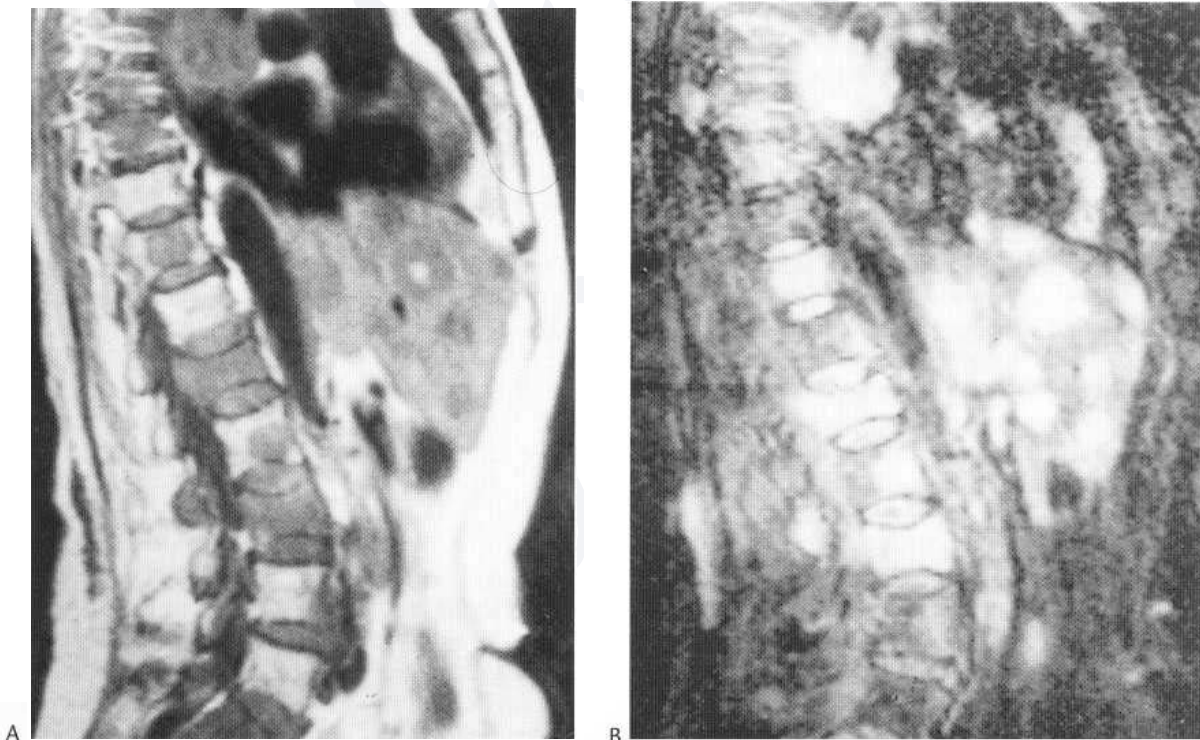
Metastatic carcinoma of the bronchus. Sagittal T_1 -weighted (A) and STIR (B) MRI sequences obtained in the body coil demonstrate extensive metastasis throughout the thoracolumbar spine and liver. The primary bronchial carcinoma is also evident.
